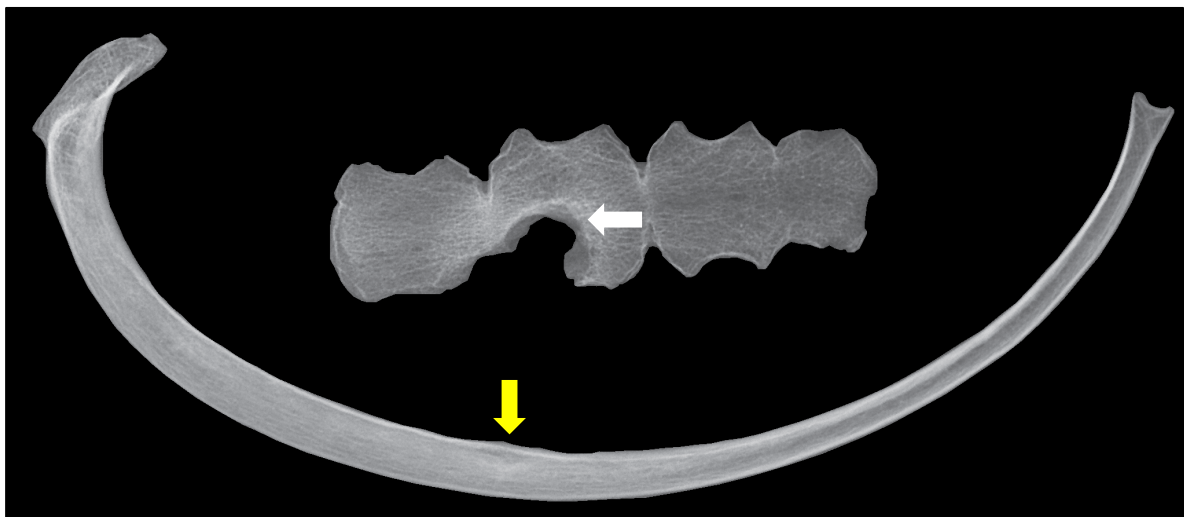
Radiographic signs consistent with tuberculosis and mycosis. Sclerotic response is only evident on the pleural aspect (white arrow). The rib lesion has completely remodelled and was deeper than observed macroscopically (yellow arrow; AT-263, young adult, Buural Uul). Image: author's own.
